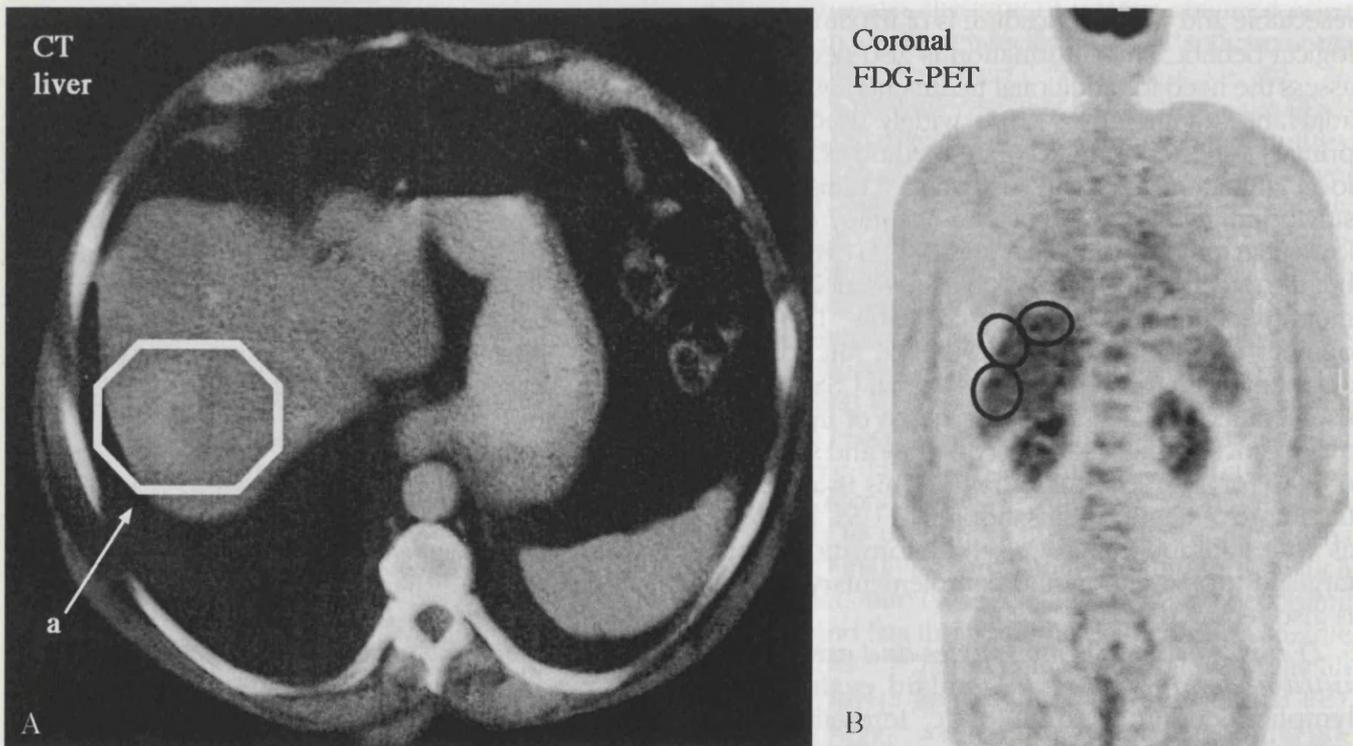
A, B) Coronal FDG-PET demonstrating at least three liver metastases from a sigmoid colon adenocarcinoma. CT scan was reported as showing a “vascular blush” (a), but no definitive diagnosis was made.
